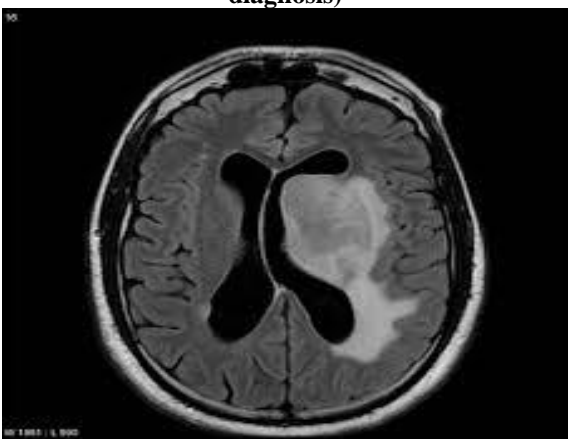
Right thalamic glioma MRI T1 contrast imageFigure 5: Left Thalamic infarct (Differential diagnosis)Figure 6: Left Thalamic lymphoma (Differential diagnosis)
